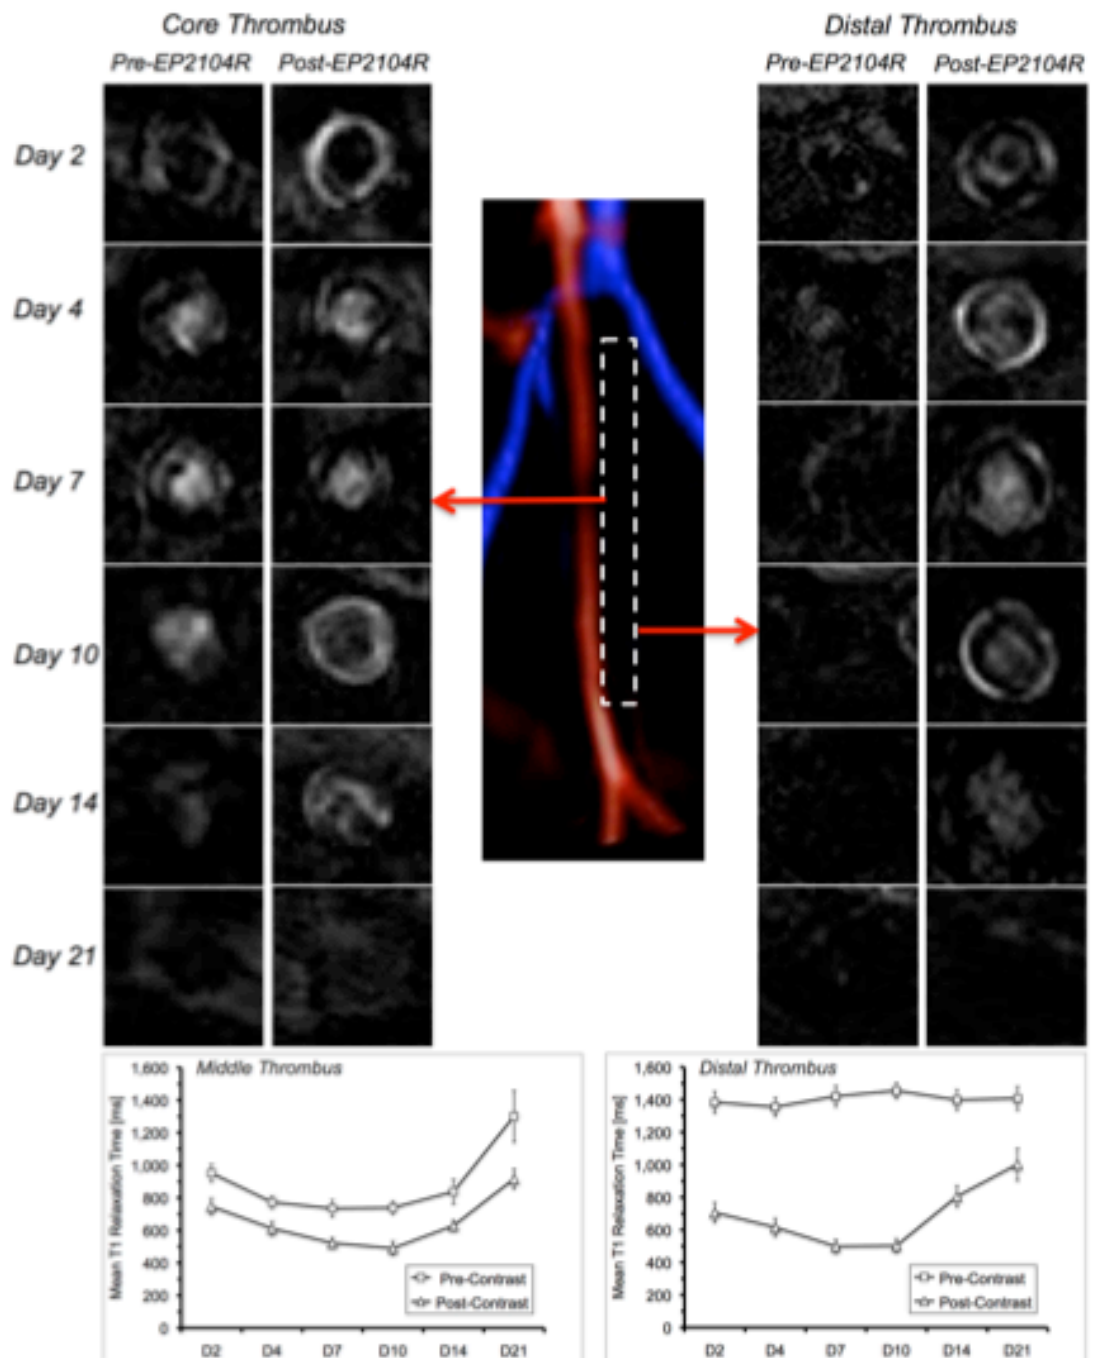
Late gadolinium enhancement inversion recovery (LGE-FSMRI) images pre- and 2 hours post-injection of EP-2104R of the middle and distal segments of thrombus at different time points post thrombus induction. High signal intensity in the LGE-IR images and low T1 relaxation times on T1 maps can be observed in the pre-contrast images of the thrombus at the middle segment between day 4 and 10 while no such effect was observed in the distal segments of the thrombus. This is due to the formation of methemoglobin in the core of the thrombus as was shown in Section 2.6. Post EP-2104R injection, contrast agent accumulation can be observed in the periphery of thrombus at day 2 both in mid and distal segments. From day 4 until day 10 increasing contrast uptake can be observed both in the mid and distal segments of thrombus and decrease of contrast uptake between day 14 to 21. The graphs show the thrombus T1 relaxation time pre and post contrast at different time points in the mid and distal segments of the thrombus. FSMRI: fibrin specific MRI.
